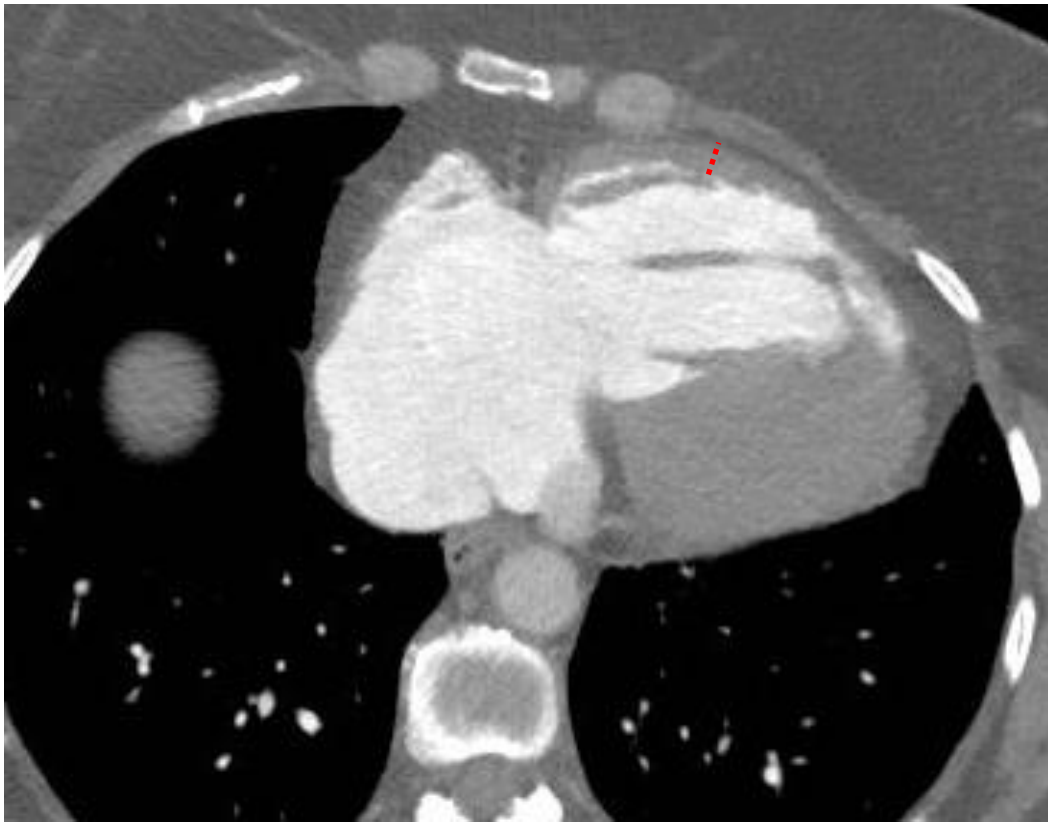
Axial CT image shows thickening of the right ventricular free wall (dotted line) in a patient with IPAH.
